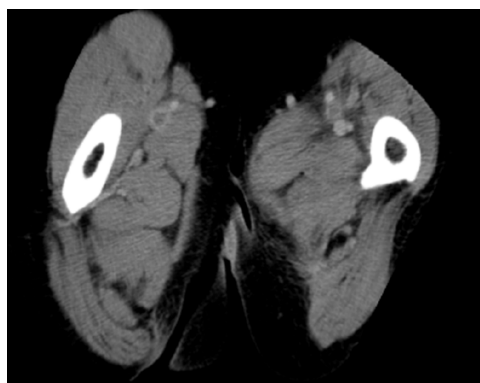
Contrast-enhanced computed tomography on hospitalization day 8. Deep vein thrombi in both femoral veins were observed.
